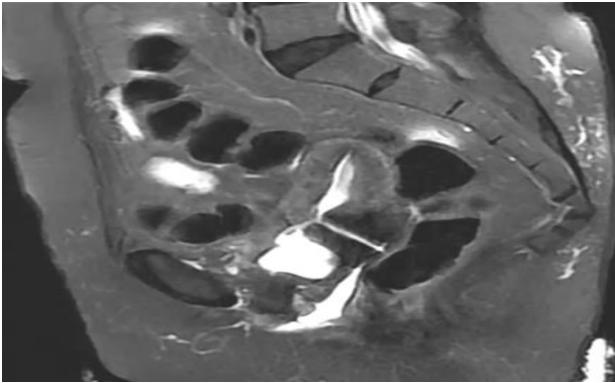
MRI with passage of contrast from bladder to cervix.
